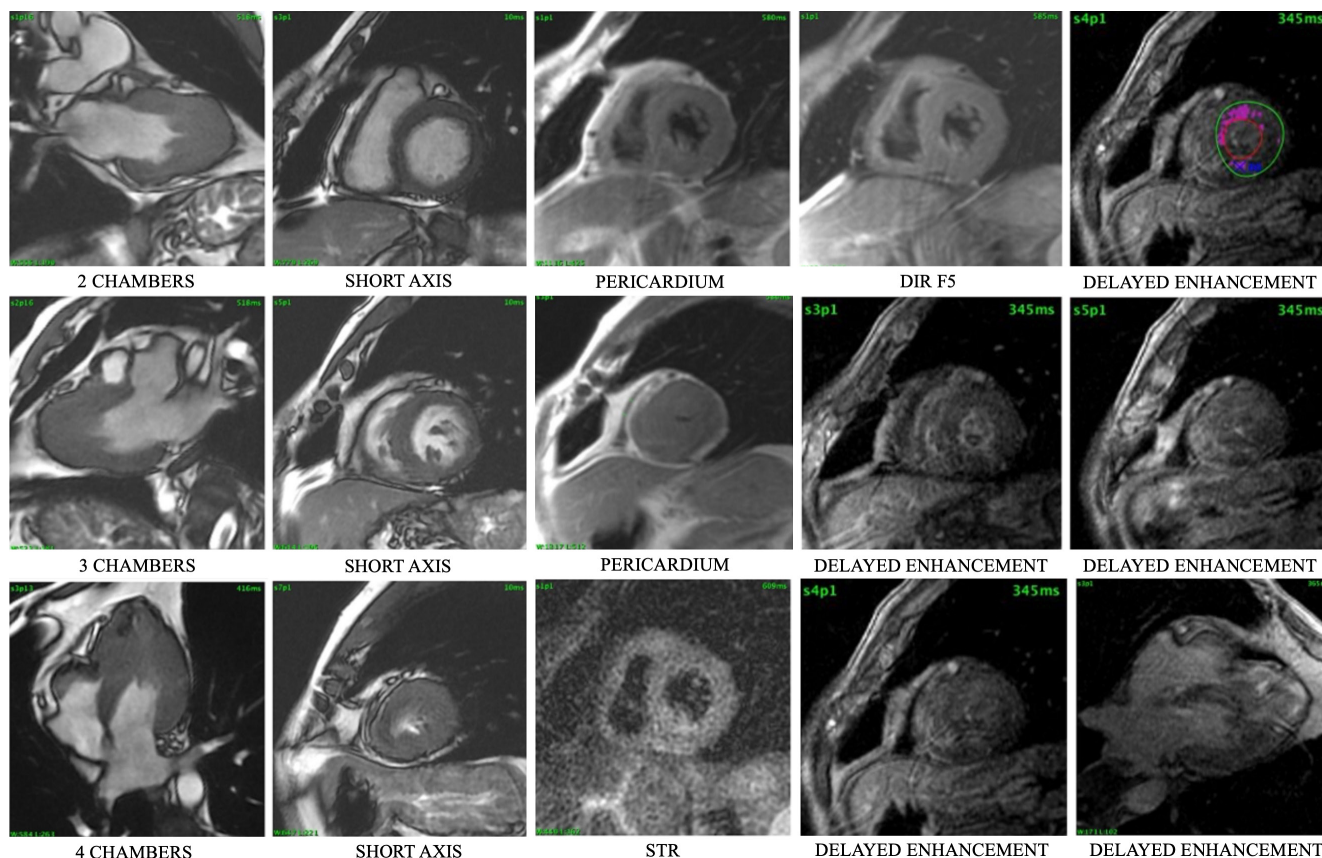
Cardiac MRI of a patient with Noonan syndrome with multiple lentigines. Apical hypertrophic heart disease. Abnormal myocardial viability study in relation to fibrosis in a zone of hypertrophy. Diffuse late mesocardium basal anteroseptal, anterior and middle anteroseptal, and apical and transmural strengthening of the apex. The late reinforcement adds 16.6 g, equivalent to 19.6% of the mass. Left ventricular ejection fraction conserved 55%. Right ventricular ejection fraction conserved 61%. Presence of an apex aneurysm.
